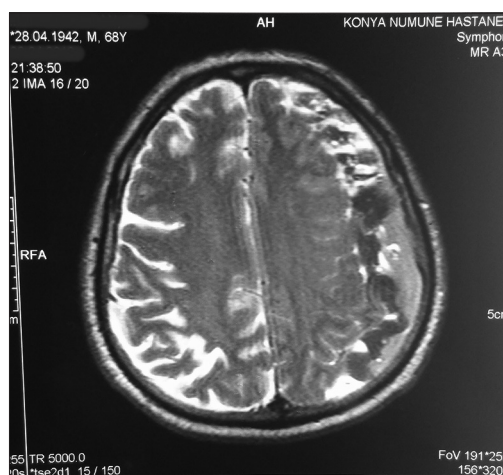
T2-weighted magnetic resonance imaging showing multiple intrahematoma loculations with hypointense web-net-like structure within the left hemispheric organized chronic subdural hematoma
